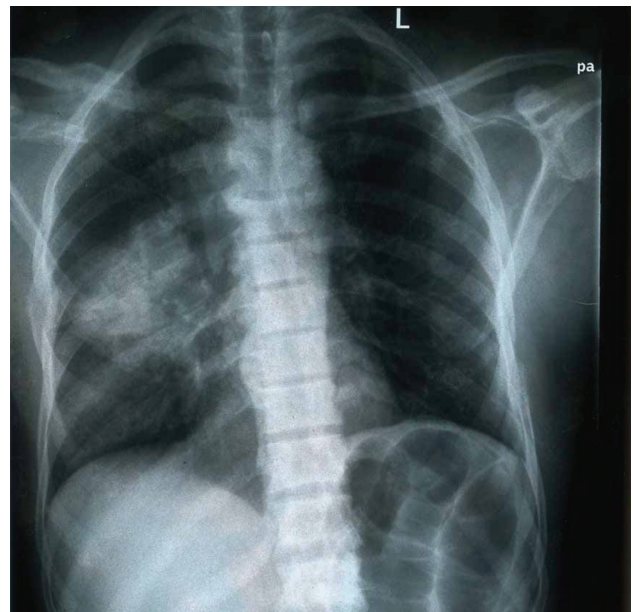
Chest X-ray revealing opacity in the middle lobe of the right lung.
